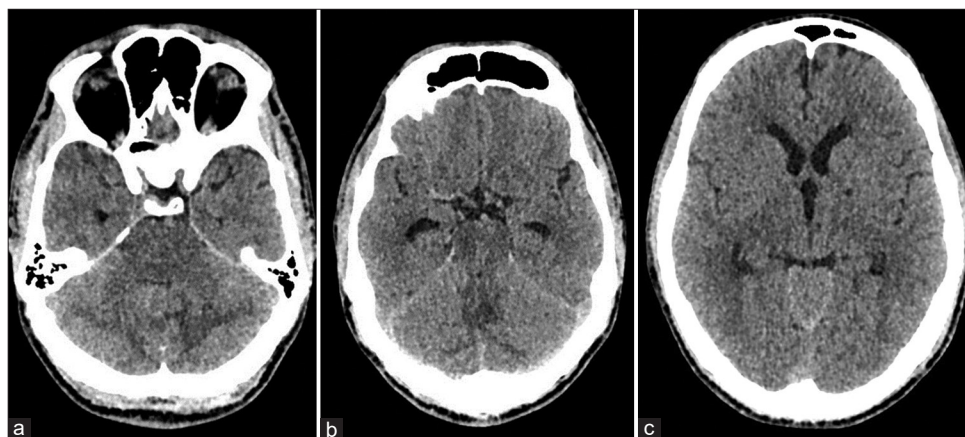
Initial noncontrast axial computed tomography head scan demonstrating (a) cerebellar oedema with effacement of the fourth ventricle, (b and c) corresponding supratentorial ventriculomegaly.
